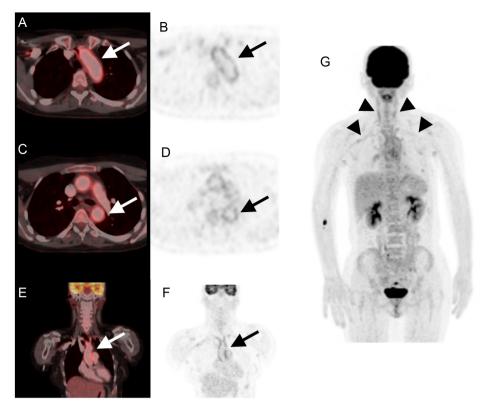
Contrast-enhanced FDG PET/CT imaging of the patient.
